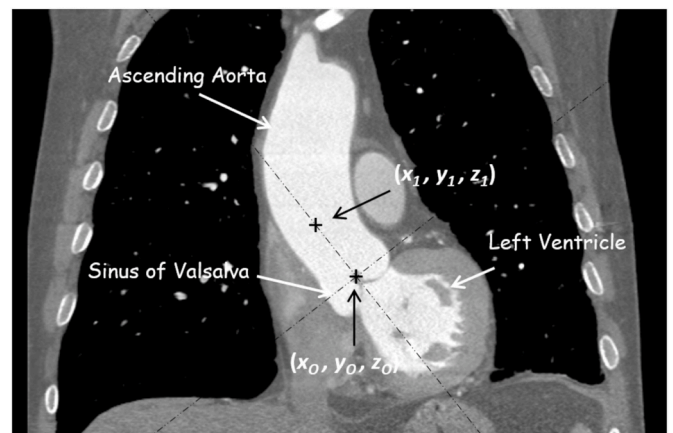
Coronal view of a CT scan. The black crosses indicate the two marks inserted by the expert, i.e., the commissure of the SOV location (x_0, y_0, z_0) and a point on the aorta's centerline (x_1, y_1, z_1) . The dashed black lines indicate the slopes of both the ascending aorta and the plane where the SOV is located that are calculated from the marks inserted by the expert.
